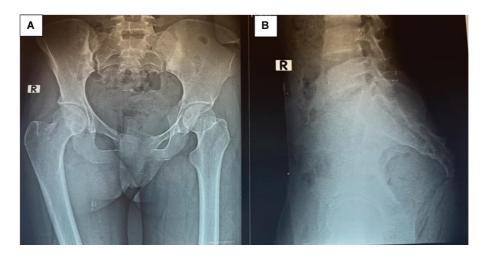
Postoperative radiograph of complete coccyx resection. (A) Front view. (B) Profile view.
